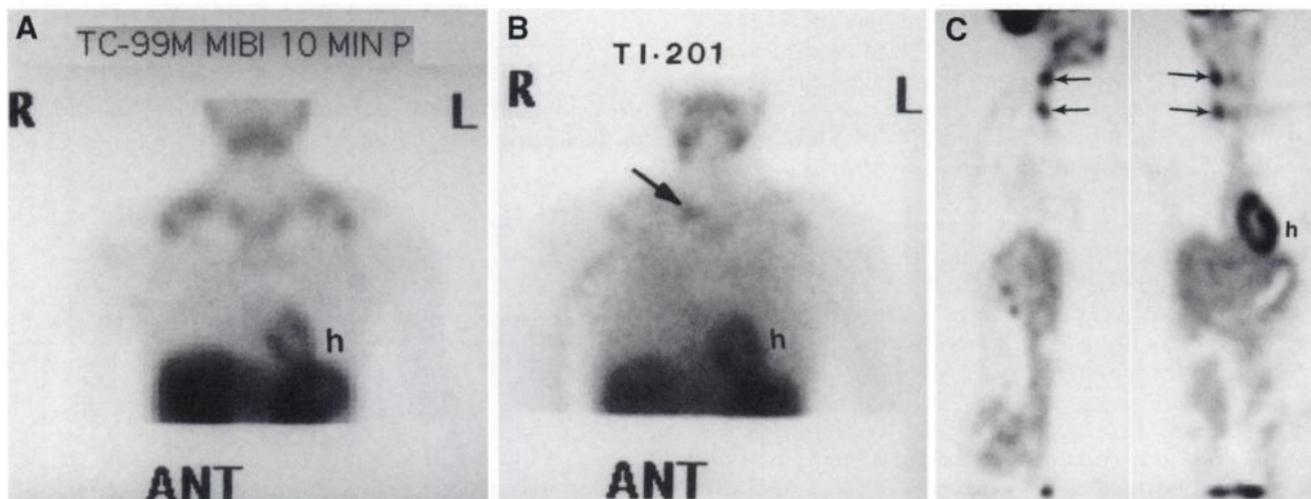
This 22-y-old woman underwent thyroidectomy and lymph node resection (two positive nodes) for tall cell variant of papillary carcinoma. ^{131}I scan was negative 1 y after 6993 MBq (189 mCi) ^{131}I therapy. (A) Methoxyisobutyl isonitrile (MIBI) scan is false-negative. (B) True-positive ^{201}Tl scan shows focal uptake in right retroclavicular region (arrow) plus asymmetric uptake in upper neck (salivary glands). (C) Total-body FDG PET scan shows two discrete foci in right neck (arrows) caused by surgical positive lymph nodes. ANT = anterior; h = heart.
